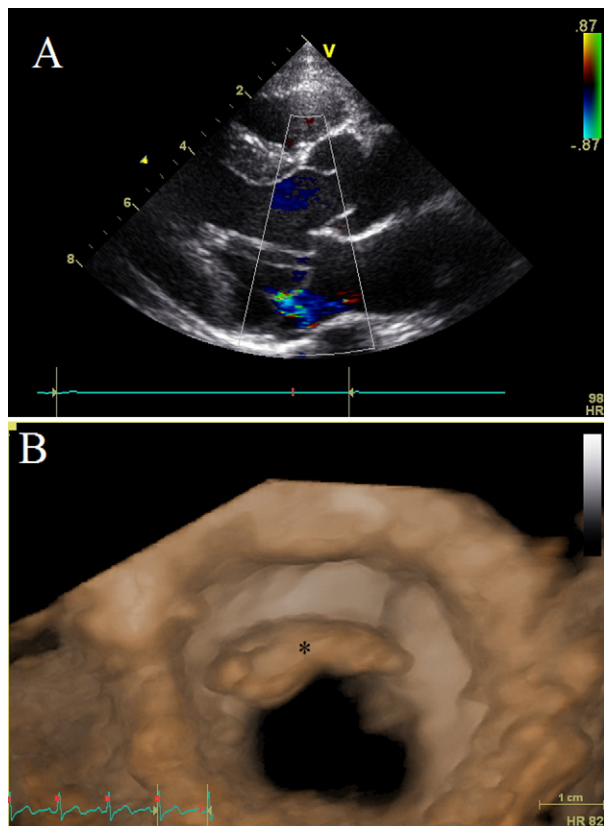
Echocardiographic images of mitral valve prolapse and myxomatous mitral valve. (A) Two-dimensional echocardiographic image of mitral valve prolapse with associated mitral regurgitation. (B) Three-dimensional echocardiographic image of myxomatous anterior mitral valve (shown with asterisk) as seen from left ventricle.
